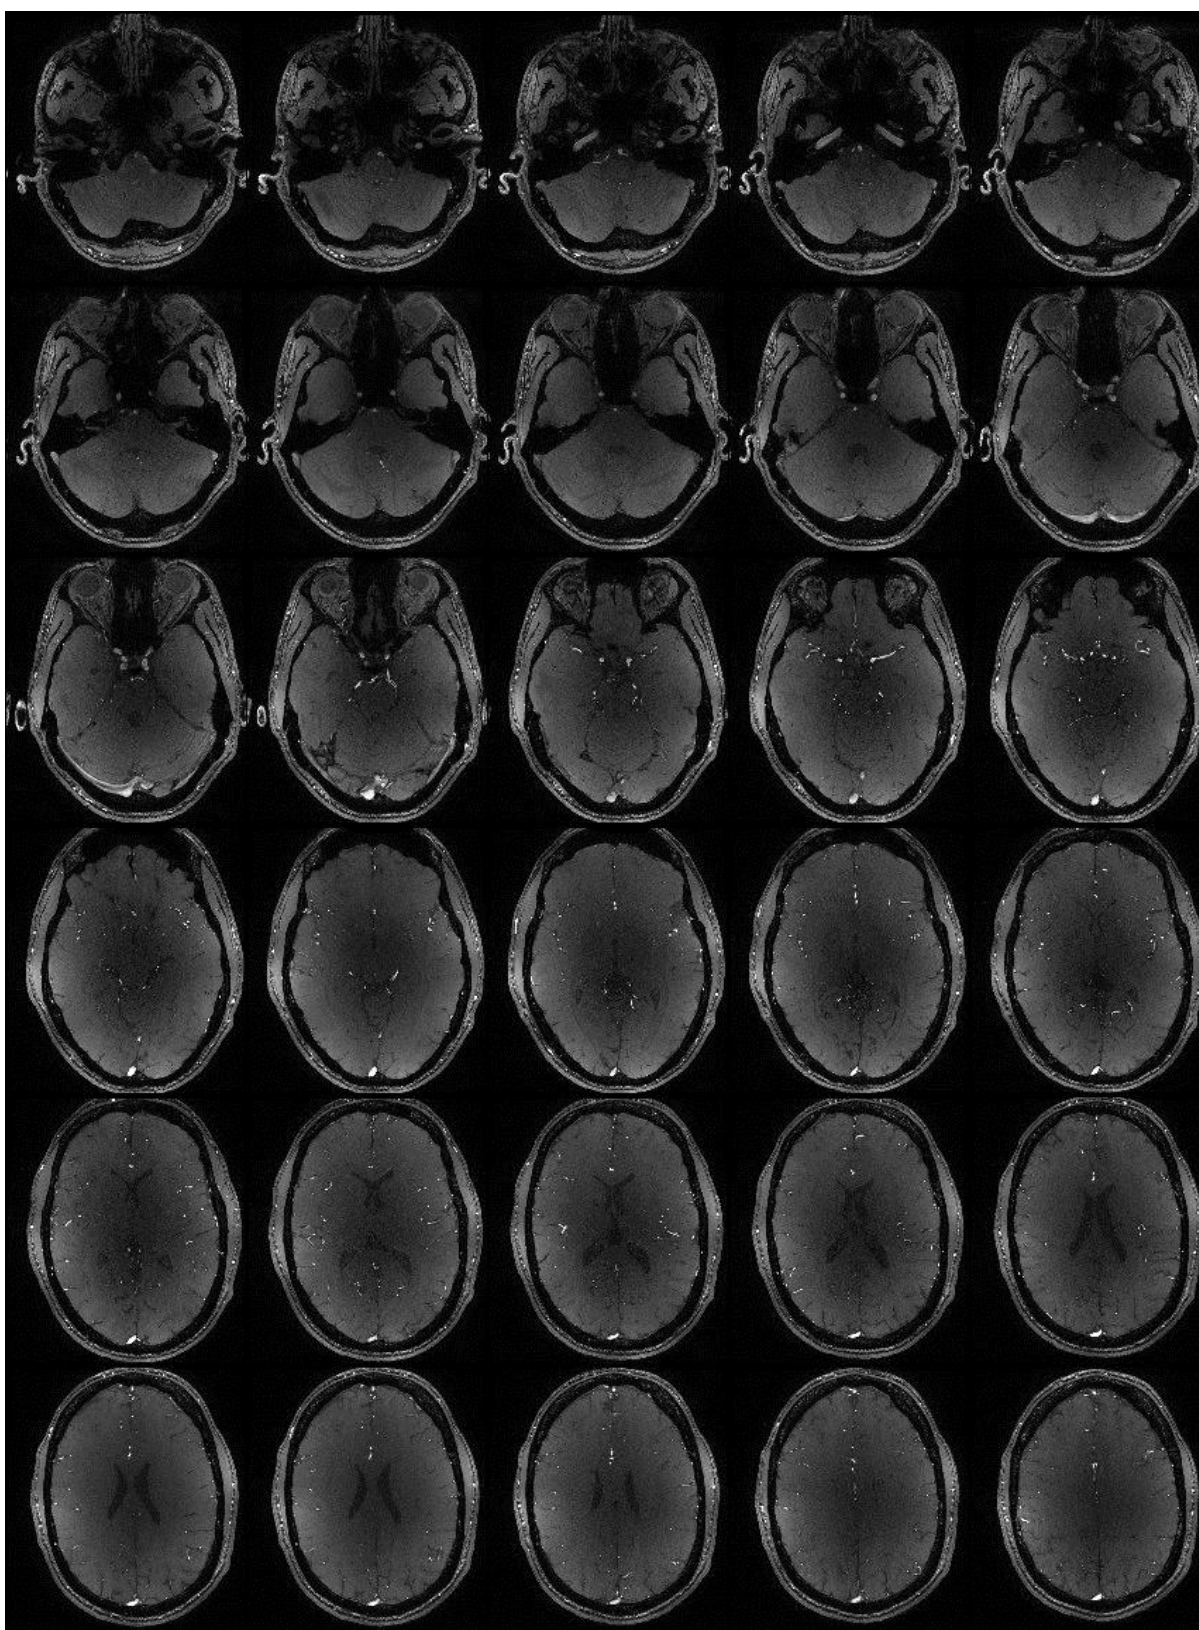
Figure B-3. MRI montage image of normal subject 3
